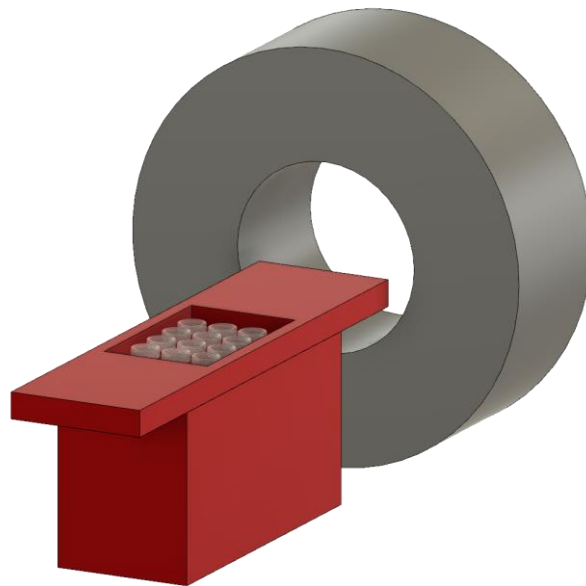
Proposed next generation prototype which has an array of transmitting coils embedded into a CT scanning bed.
